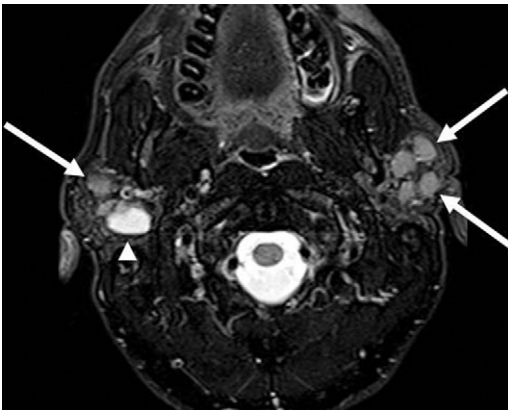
Pattern of multiple parotid lesions. Axial fat-saturated T2-weighted image in a patient with HIV showing multiple solid (*arrows*) and cystic (*arrowhead*) lesions in both parotid glands, representing benign lymphoepithelial lesions.
